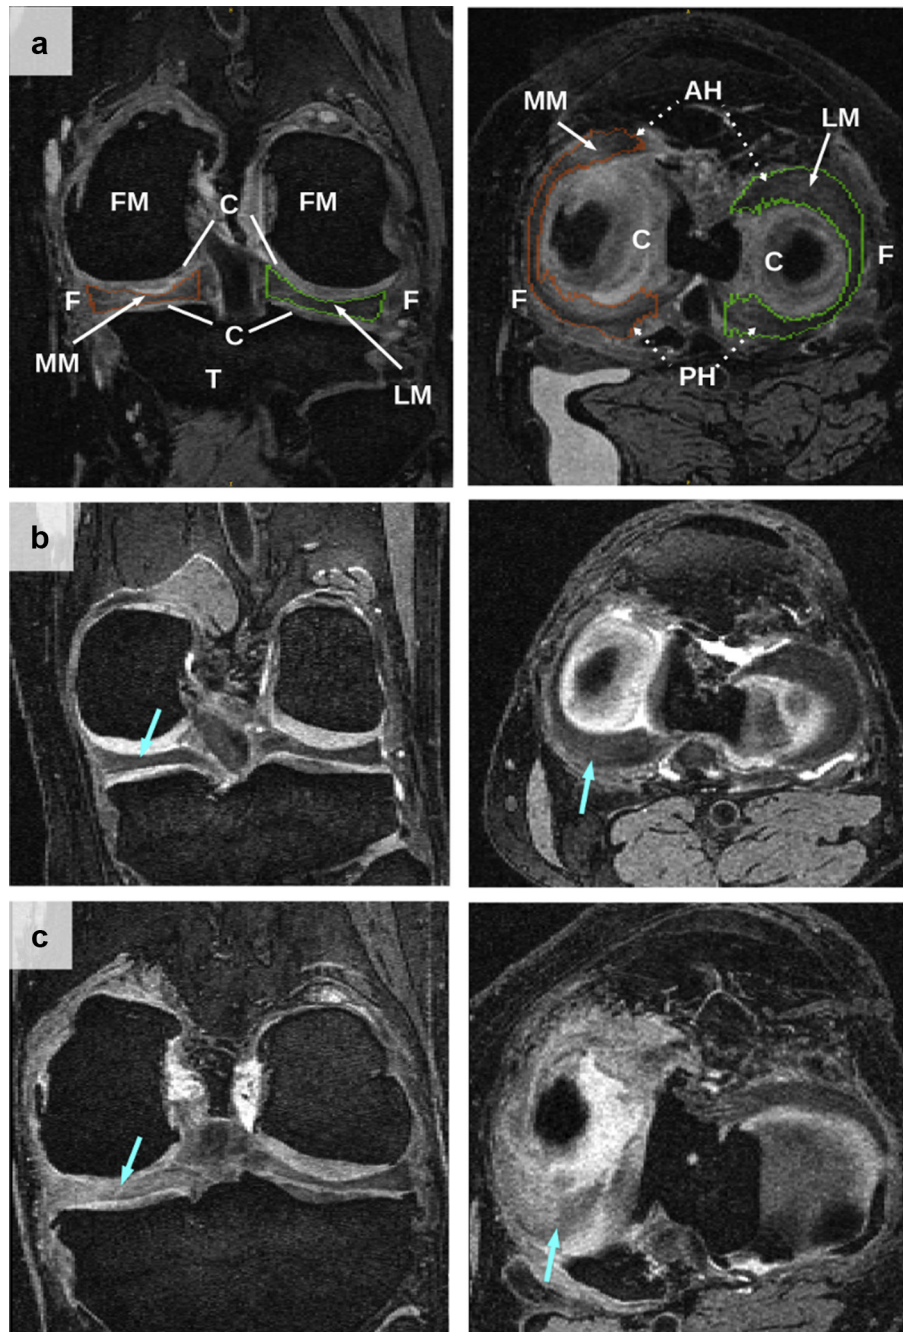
(a) Manual segmentation of the menisci in a 3D weDESS MR image acquired in the sagittal plane (patient 9,056,363, female, age 57, height 168.5 cm, body mass index (BMI) 31.8 kg/m², rOA grade III). (left) Coronal view, MM = medial meniscus, LM = lateral meniscus, FM = femur, T = tibia, C = cartilage, F = fat. (Right) Axial view, AH = anterior horn, PH = posterior horn. (b) A 3D sagittal weDESS MR image of healthy menisci demonstrating high tissue intensity homogeneity and clear demarcation between the surrounding cartilage and fat tissues in (left) coronal and (right) axial views (patient 9,323,403, male, age 51, height 161.8 cm, BMI 27.4, rOA grade 0). (c) The menisci in a patient with moderate/severe rOA of the knee joint demonstrating “lesions” in the menisci in (left) coronal and (right) axial views (patient 9,800,677, male, age 65, 184.7 cm, BMI 31.1 kg/m², rOA grade III).
